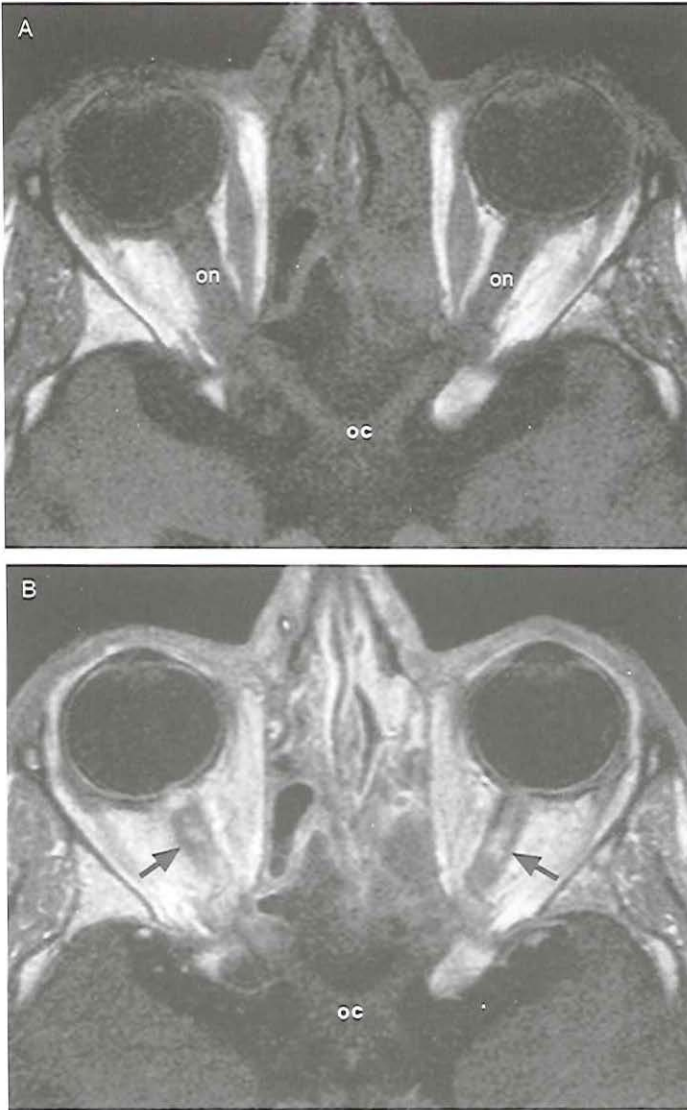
T1-weighted transverse MR-images at the level of the optic nerves (on) and optic chiasm (oc) prior to (a) and after intravenous gadolinium-DTPA (b). The patchy enhancing lesions (arrow) within the optic nerves are typical for radiation-induced optic neuropathy.
